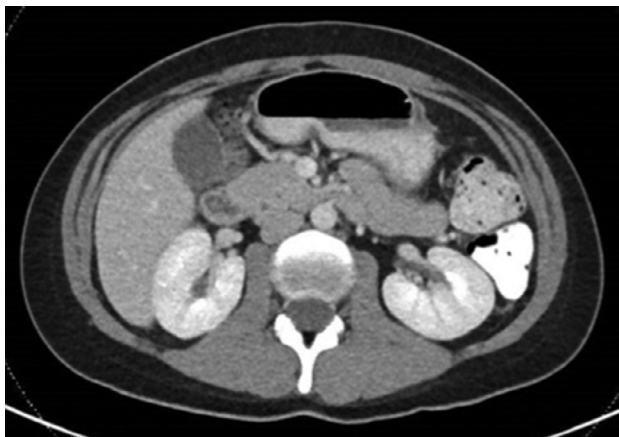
Axial cut of CT Abdomen on POD7 showing resolution of pneumoperitoneum and improvement in subcutaneous emphysema
